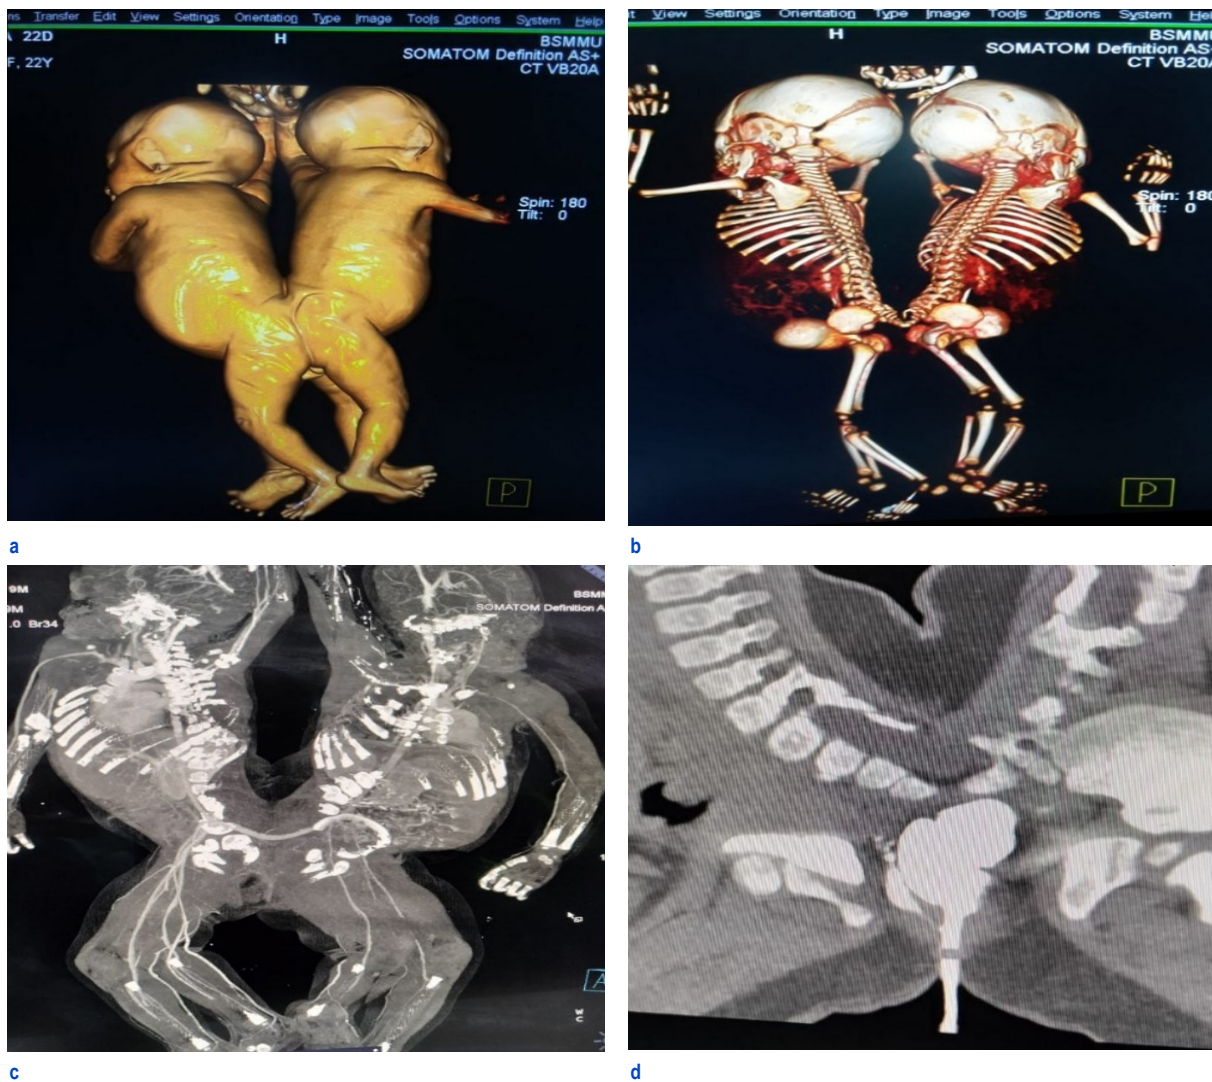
On CT scan 3D volume rendering image of the conjoined twins shows (a) fusion of soft tissue in the lower back and (b) fused vertebra at the level of S2. (c) with P/R contrast, two separate rectums for each baby are present, but there is a single anal canal. (d) CT-aortogram showed the division of the aorta at the S5 level while the accessory branch of the aorta joined together
